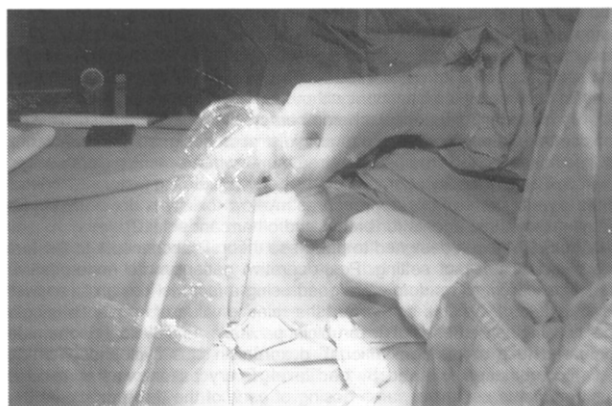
Intraoperative ultrasound guided breast biopsy.
